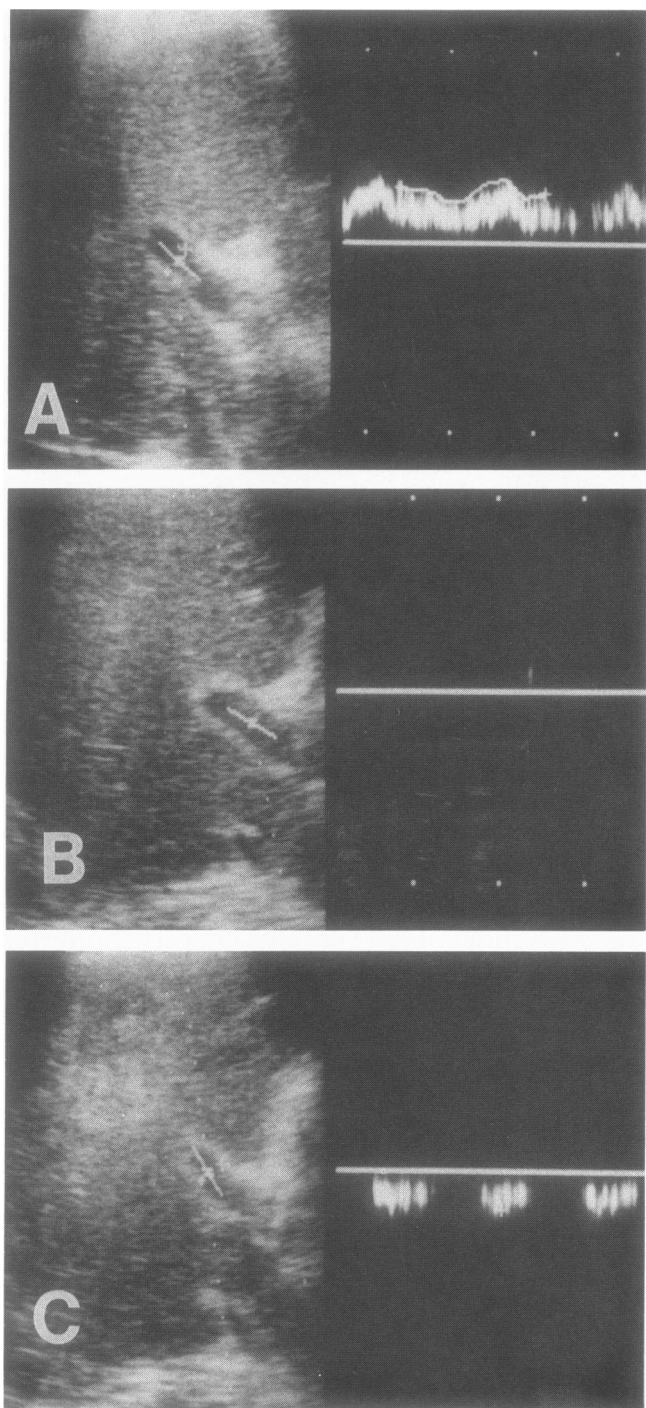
Changes in portal flow direction in patient 8 are demonstrated. The postoperative portal flow in the right branch was hepatopetal initially (A), but subsequently, Doppler signals could no longer be obtained (B). The flow reversed on the fifth postoperative day, and the direction did not recover to hepatopetal flow (C).
